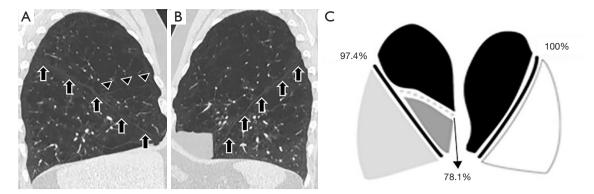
The HRCT and the StratX<sup>®</sup> images demonstrating interlobar FI. (A) The HRCT image shows visually that the right major fissure is intact (arrows), but the minor fissure is not (arrowheads). (B) The HRCT image shows visually that the left major fissure is intact (arrows). (C) The StratX<sup>®</sup> lung report shows that bilateral major FI is ≥95% (continuous black line), and the right minor FI is <80% (dotted grey line). HRCT, high-resolution computed tomography; StratX<sup>®</sup>, quantitative lung computed tomography; FI, fissure integrity.
